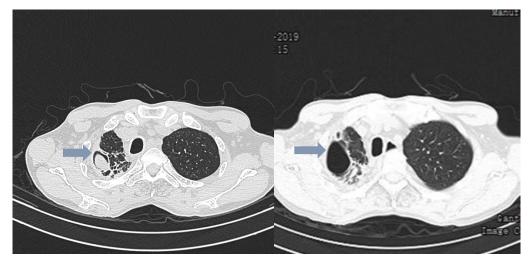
Comparative CT Thorax after 6 months. Image on the right shows disappearance of the fungal ball as seen in previous CT (shown by arrows)
